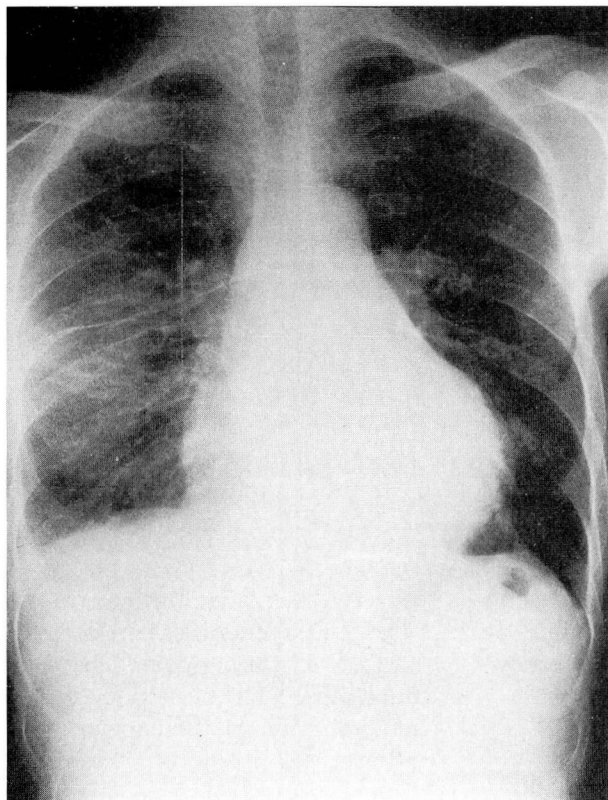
Chest roentgenogram on admission, showing cardiomegaly, a small right pleural effusion, and a large rounded opacity behind the left cardiac border.
